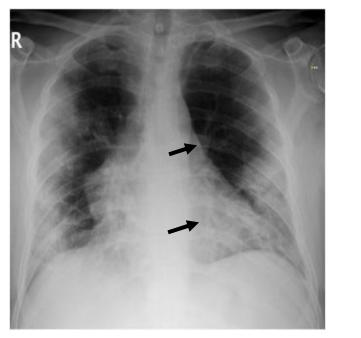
Bilateral peripheral multifocal opacities demonstrated in the characteristic chest radiograph(43)
